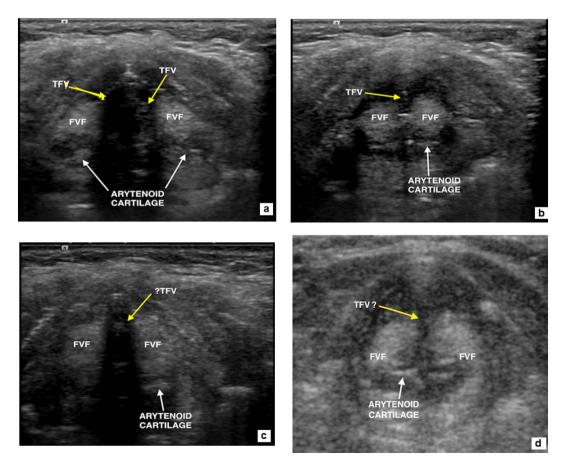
a–d Gray scale images of true vocal folds (TVF, yellow arrows) and false vocal folds (FVF) in transcutaneous laryngeal sonography obtained from two healthy subjects. Transverse section of both left and right TVFs and FVFs in abduction (a) and in adduction (b) are clearly visualized in a 32 years old healthy woman. However, TVFs (yellow arrows with question mark) are not optimal in abduction (c) or in adduction (d) in a 65 years old man because the thyroid cartilage obscures sound beams penetrating to the TVF. An important note is that bilateral FVFs are visualized well in abduction and adduction in both subjects.
